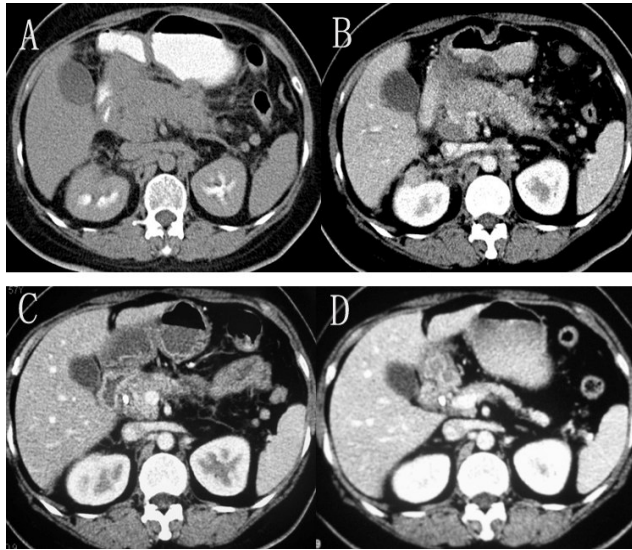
The CT scan of the tumor. A and B: The lesion in duodenum invaded porta hepatis, head of pancreas, omentum bursa, peritoneum lymph nodes and right adrenal gland. C: Most neoplasm disappeared and only a nodule (2.0*1.5 cm) left in right adrenal gland. After 6 cycles of FOLFOX4. D: All the lesions disappeared after 12 cycles of FOLFOX4
